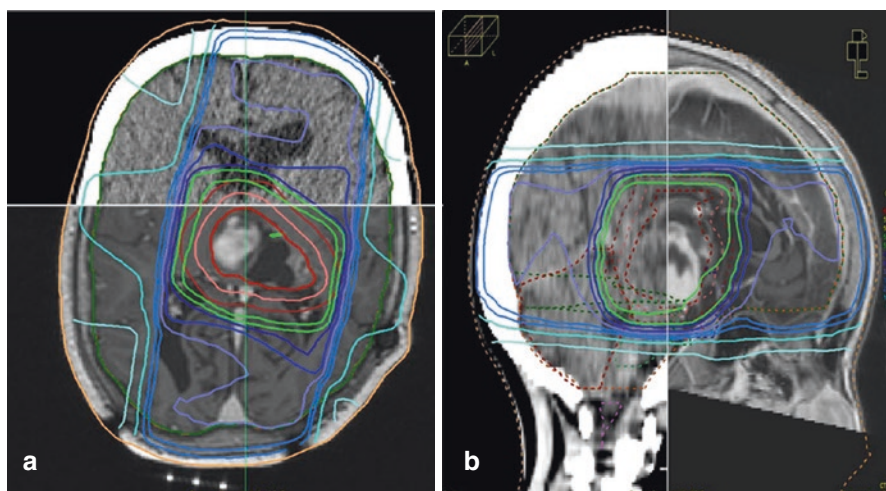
A 10-year-old boy with pilocytic astrocytoma s/p biopsy, treated with three-dimensional conformal radiotherapy. The gross tumour volume (GTV) is outlined in *red*, clinical target volume (CTV, 5 mm) in *pink* and planning target volume (PTV, 5 mm) in *magenta*. (a) Transverse slice (b) Sagittal slice. Image fusion with T-1 weighted, contrast-enhanced MRI was performed. (a) Transverse slice (b) Sagittal slice. The 51.3 Gy isodose line (*outer green*) encompasses the entire PTV
